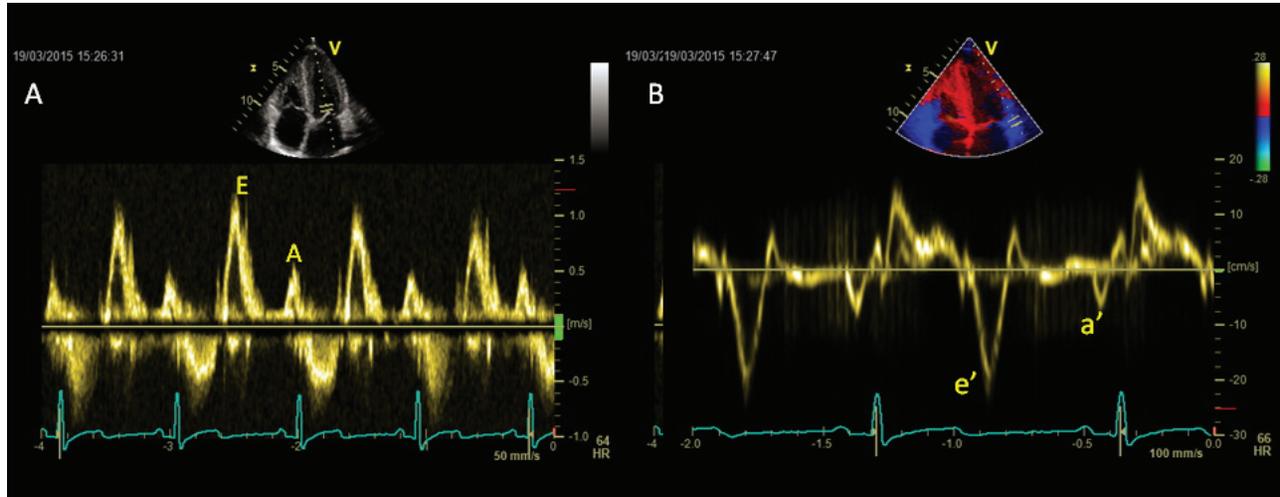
Transmitral flow pattern (left panel, 1a) and tissue Doppler (right panel, 1b) of an endurance athlete, showing supranormal diastolic function both at a global and regional level.
